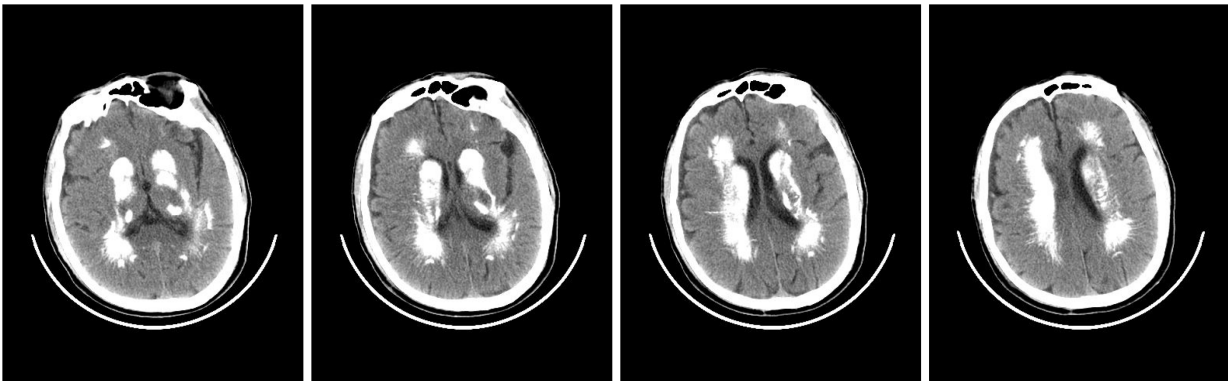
Computed tomography of the brain showed multiple calcifications in the dentate nucleus and basal ganglia of bilateral cerebellum hemispheres.
